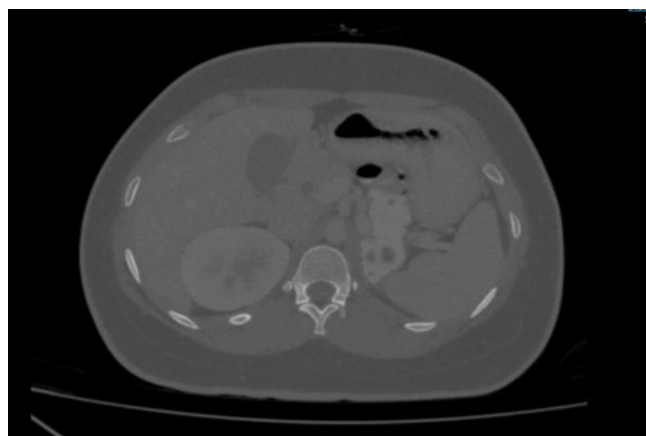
Abdomen and Pelvis computed tomography scan at the patient's pancreas level; the pancreas, right adrenal gland, and spleen are unremarkable. Absent left kidney and left adrenal gland. Regular enhancement of the right kidney with the extrarenal pelvis. The right renal cyst noted at the lower pole measures 1.4cm x 2.0cm. There are no complex features within. No calculus or hydronephrosis.
